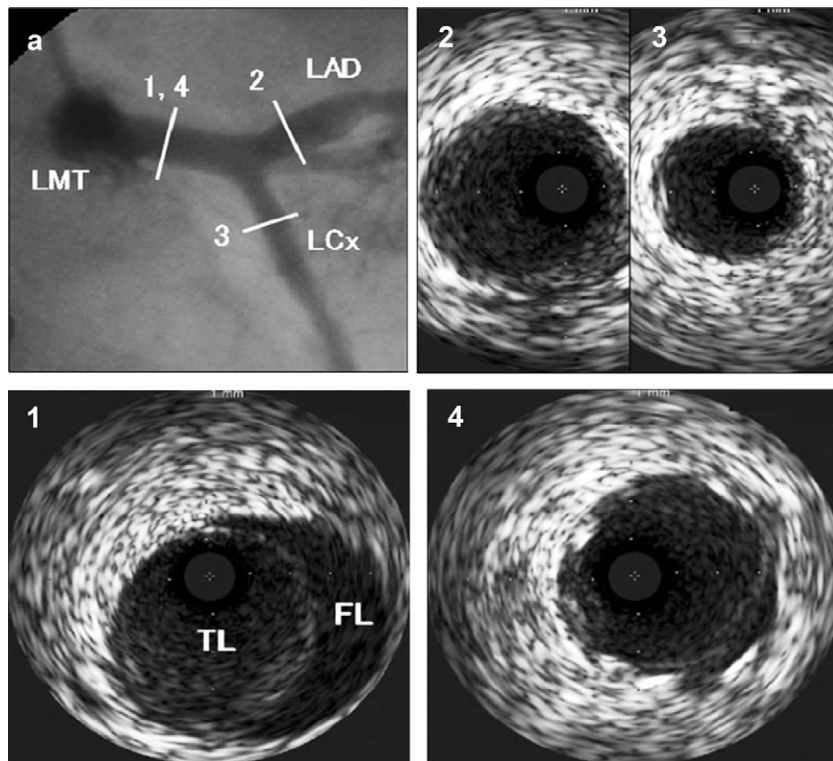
Image of left coronary angiography from right caudal view (a) and images of intravascular ultrasound (IVUS) at left coronary artery (1–4). IVUS revealed aortic dissection extending to left main coronary artery (1). Stent was deployed to the ostium to body of left main coronary artery (4). LAD, left anterior descending artery; LCX, left circumflex artery; LMT, left main trunk; FL, false lumen; TL, true lumen.
